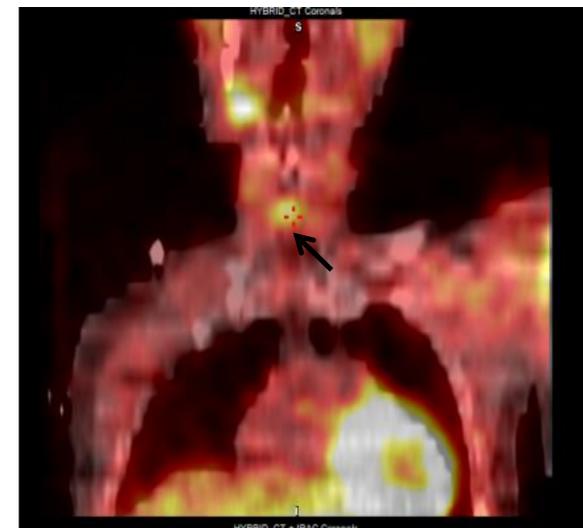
Delayed multiplanar SPECT images of the neck showing increased activity in the isthmus region with additional residual uptake over the left lower pole at the site of the initial surgery
